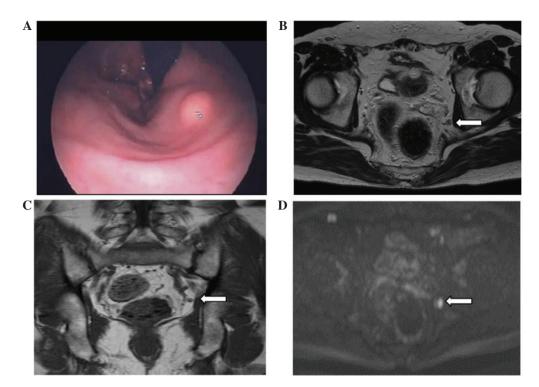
(A) Colonoscopy revealed a hemispheric submucosal tumor, 7 mm in diameter, at the low rectum without central depression and ulceration. The (B) T2-eighted axial magnetic resonance image, (C) coronal image and (D) diffusion weighted image revealed lymph node swelling at the left side obturator external iliac space (arrow). The maximum size was 7 mm.
